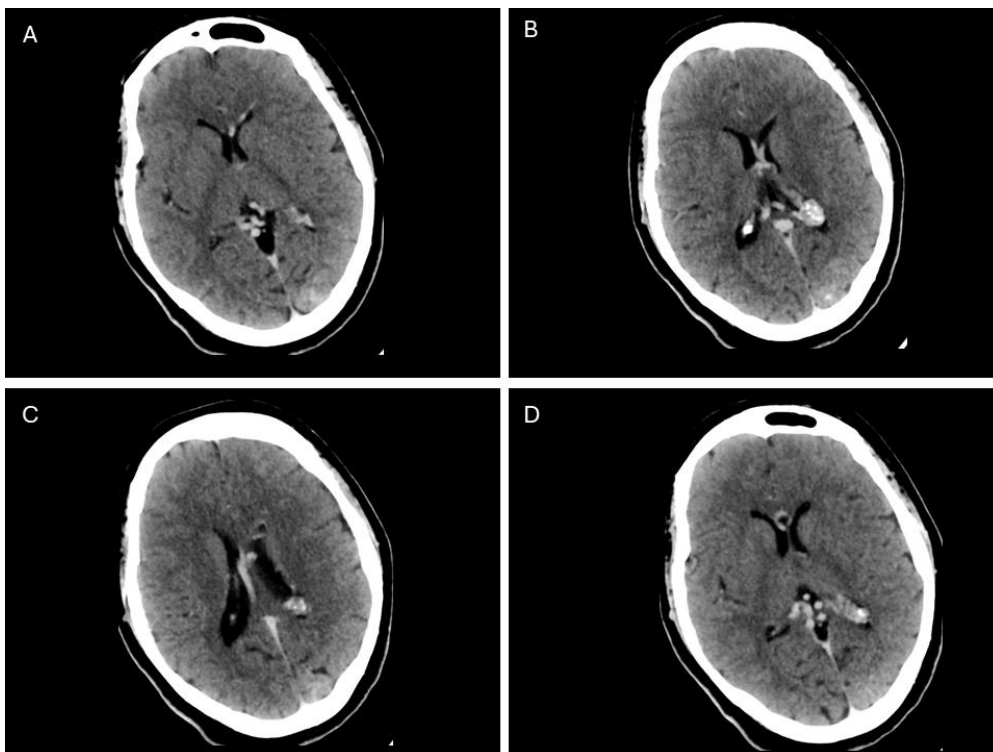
Post-contrast brain CT images
